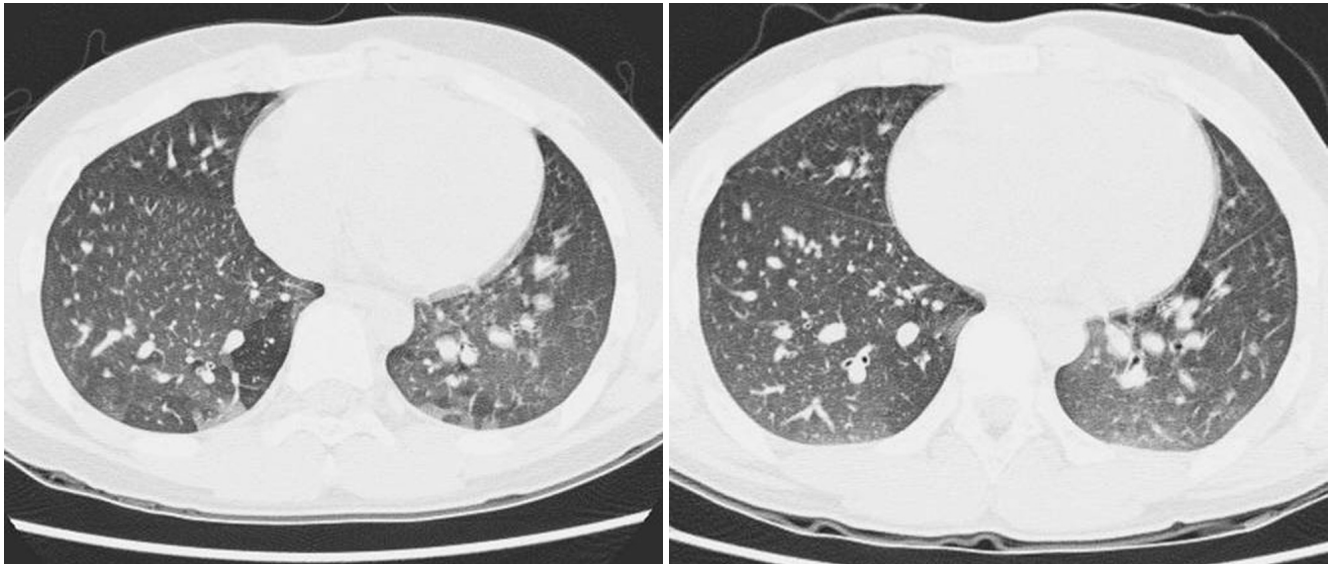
Patient 8. A 9-year-old-male presented with dyspnea, cough, and hoarseness. Multifocal air trapping was shown on full expiratory HRCT scan (A) after eight months of exposure to irritant gas. The result of PFT of that time was positive. After 12 months of treatment (B), the extent of air trapping and the density of lungs were decreased, and the PFT was negative. Also, cough and dyspnea on exertion was improved.
